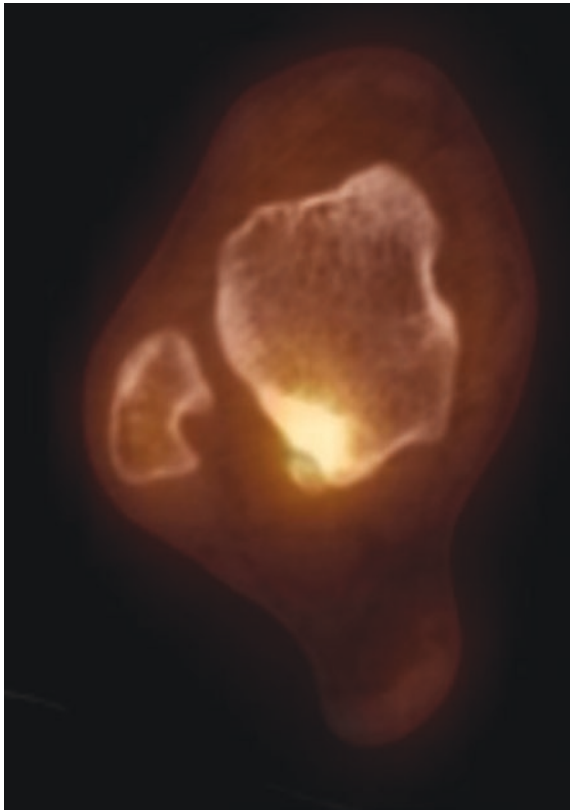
SPECT showing stress fracture of posterior talus
